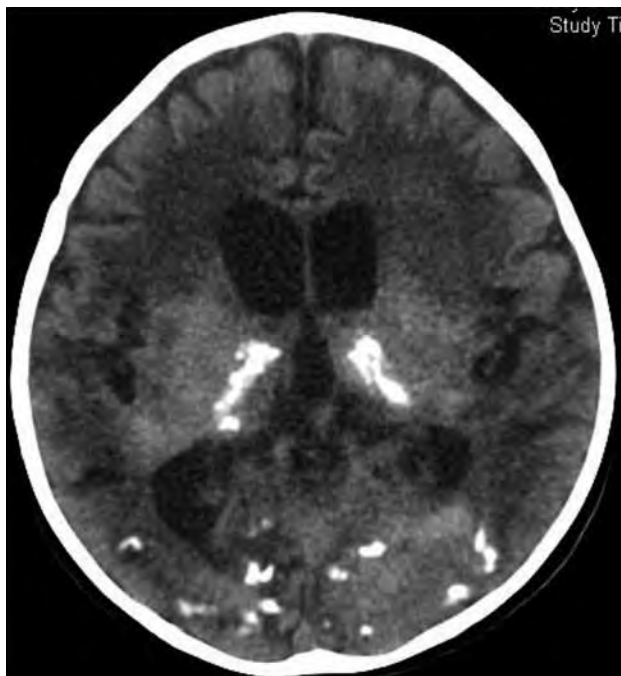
Computed tomography scan showing bilateral cortical and thalamic calcifications in patient 1.
